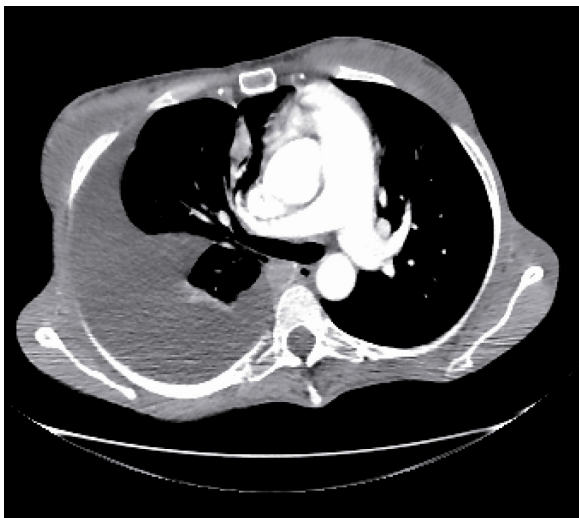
Thoracic axial CT-scan showing a right pleural effusion
